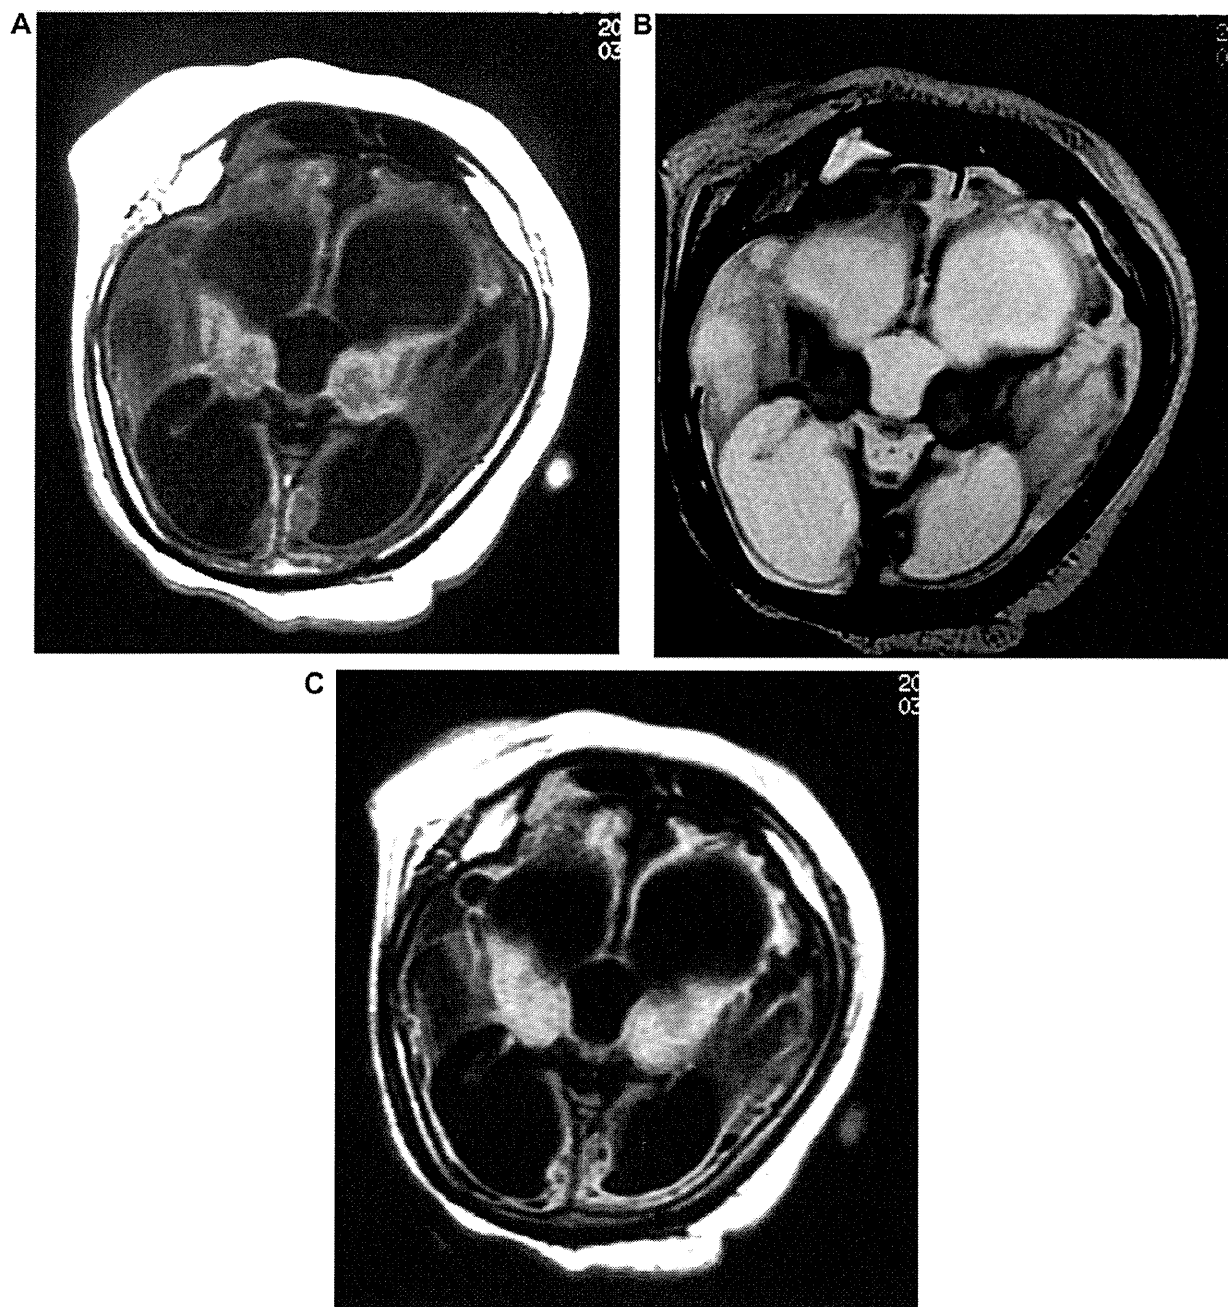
MRI at 32 years of age. T1-weighted (A) and T2-weighted (B) and fluid attenuated inversion recovery (FLAIR) (C) axial images show marked dilatation of bilateral ventricles and marked cerebral atrophy with cystic formation predominant in the white matter. Significant atrophy and T2 hyperintensity are noted on the basal ganglia and thalami.
